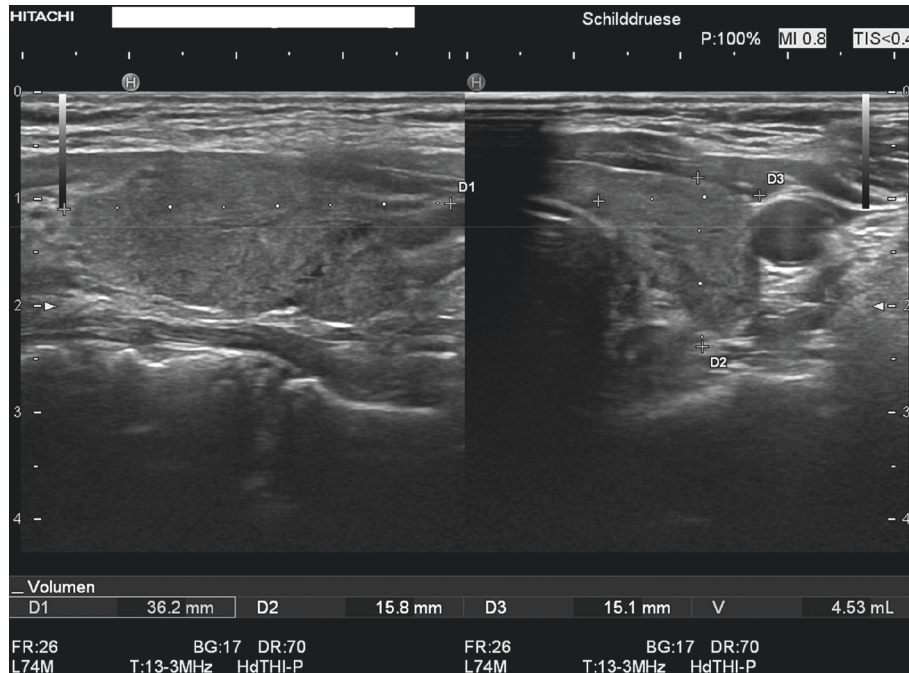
This ultrasound picture shows a hypoechoic texture with pseudonodular lesions typical for SAT.
